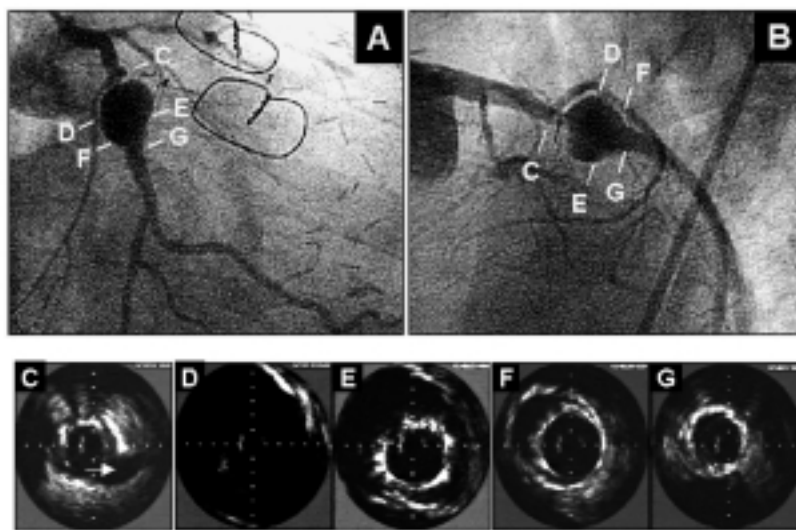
Angiography (A, B) and intravascular ultrasound imaging (C-G) show the presence of a true aneurysm beginning a few mm proximal to the stent and extending to the middle of the stent. A: right anterior oblique caudal view. B: left anterior oblique cranial view. C: vessel proximal to the aneurysm. The origin of a small atrial branch can be appreciated (arrow). D: aneurysm with a maximum diameter exceeding 12 mm, which is the size of the field of the intravascular ultrasound system. E, F: proximal half of the Palmaz-Schatz stent surrounded by the aneurysm. In F, there is no contact between the stent struts and the aneurysmal wall over the entire circumference. G: distal half of the stent fully attached to the vessel wall. The minimal area of the stent is 12.1 mm².
